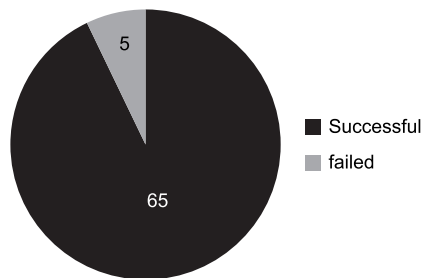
Outcome of ultrasound guided tube drainage.
